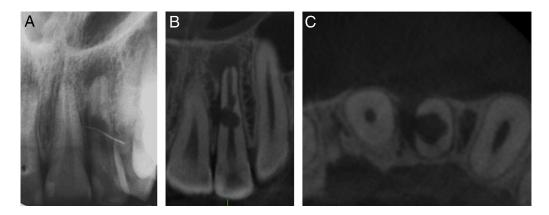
(A) The gutta-percha point tracing the sinus tract points at the lateral perforation of the internal resorption. (B) The CBCT image in the frontal projection demonstrates the dimensions of the internal resorption and the apical and lateral radiolucencies. (C) In the axial reconstruction of CBCT images, the perforation is clearly visible.
